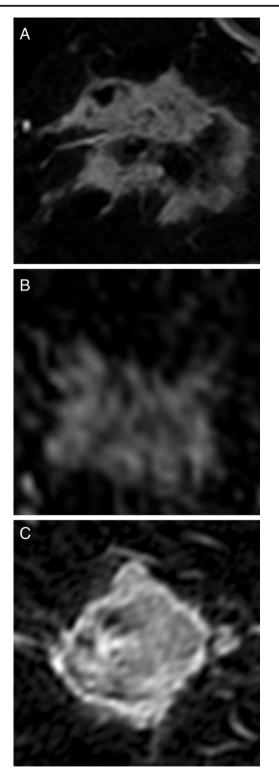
a–c Examples of T1 postcontrast breast MRI images of tumors that underwent CNN evaluation in our study from patients with partial response
